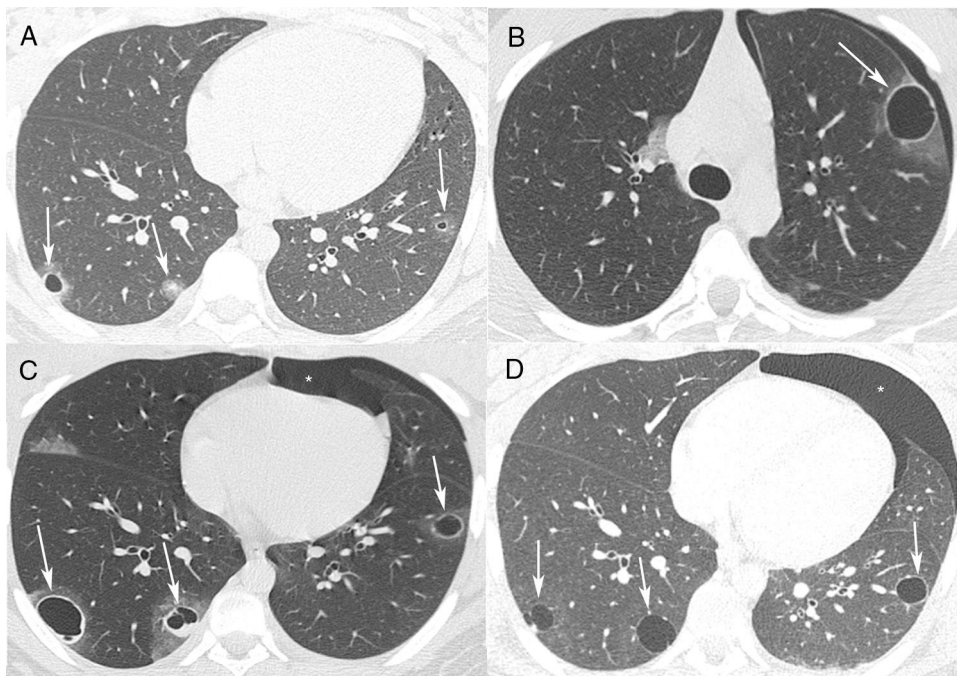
(A) Axial chest CT with pulmonary window settings shows bilateral small pulmonary nodules, two of which are cavitated (arrows). (B, C) CT performed 4 months later demonstrates a left spontaneous pneumothorax (asterisk) and growth of the nodules, which now present with relatively thick walls and ground-glass halos (arrows). (D) CT performed 1 year after A shows a new left pneumothorax (asterisk) and evolution of the cavitated nodules into thin-walled cystic lesions (arrows).
